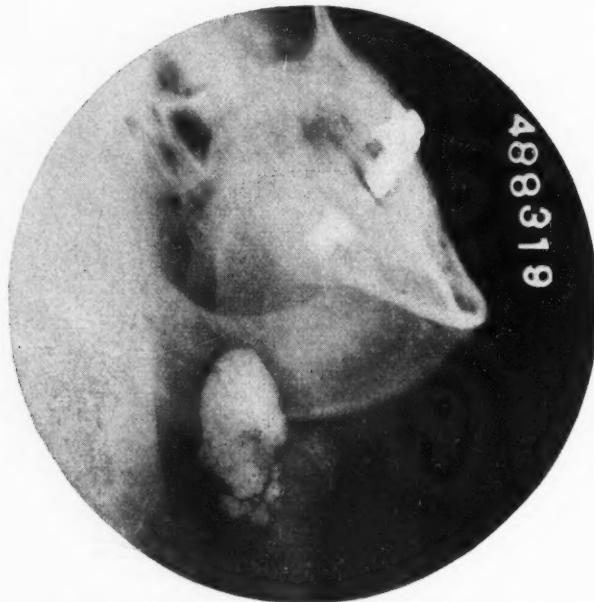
Retouched roentgenogram. The multiple stones in the submaxillary salivary gland, and one very large stone may be seen.
